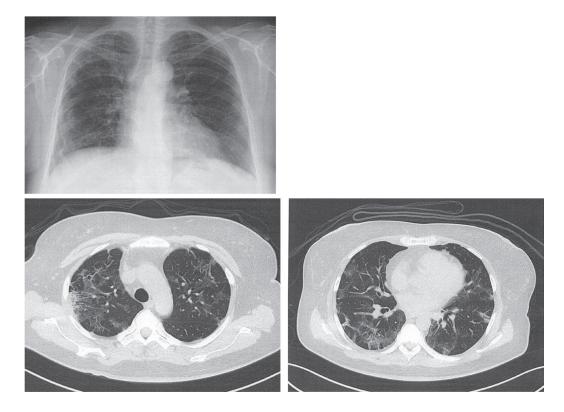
A. Chest X-ray and computed tomography scans (transverse plane) of the patient at the time of admission (day 0).
